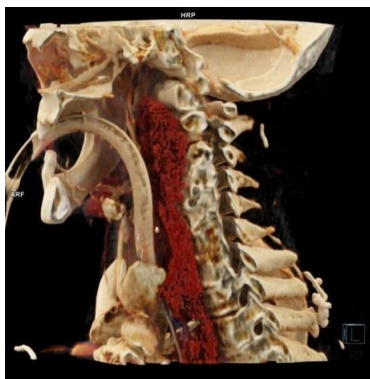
Side view of CT reconstruction showing a large and extensive retropharyngeal hematoma (red).
